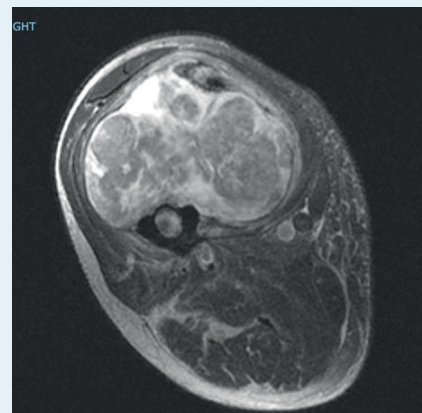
Pre-operative fluid weighted axial MRI of right thigh demonstrating significant bone erosion and intraosseous marrow signal changes.
